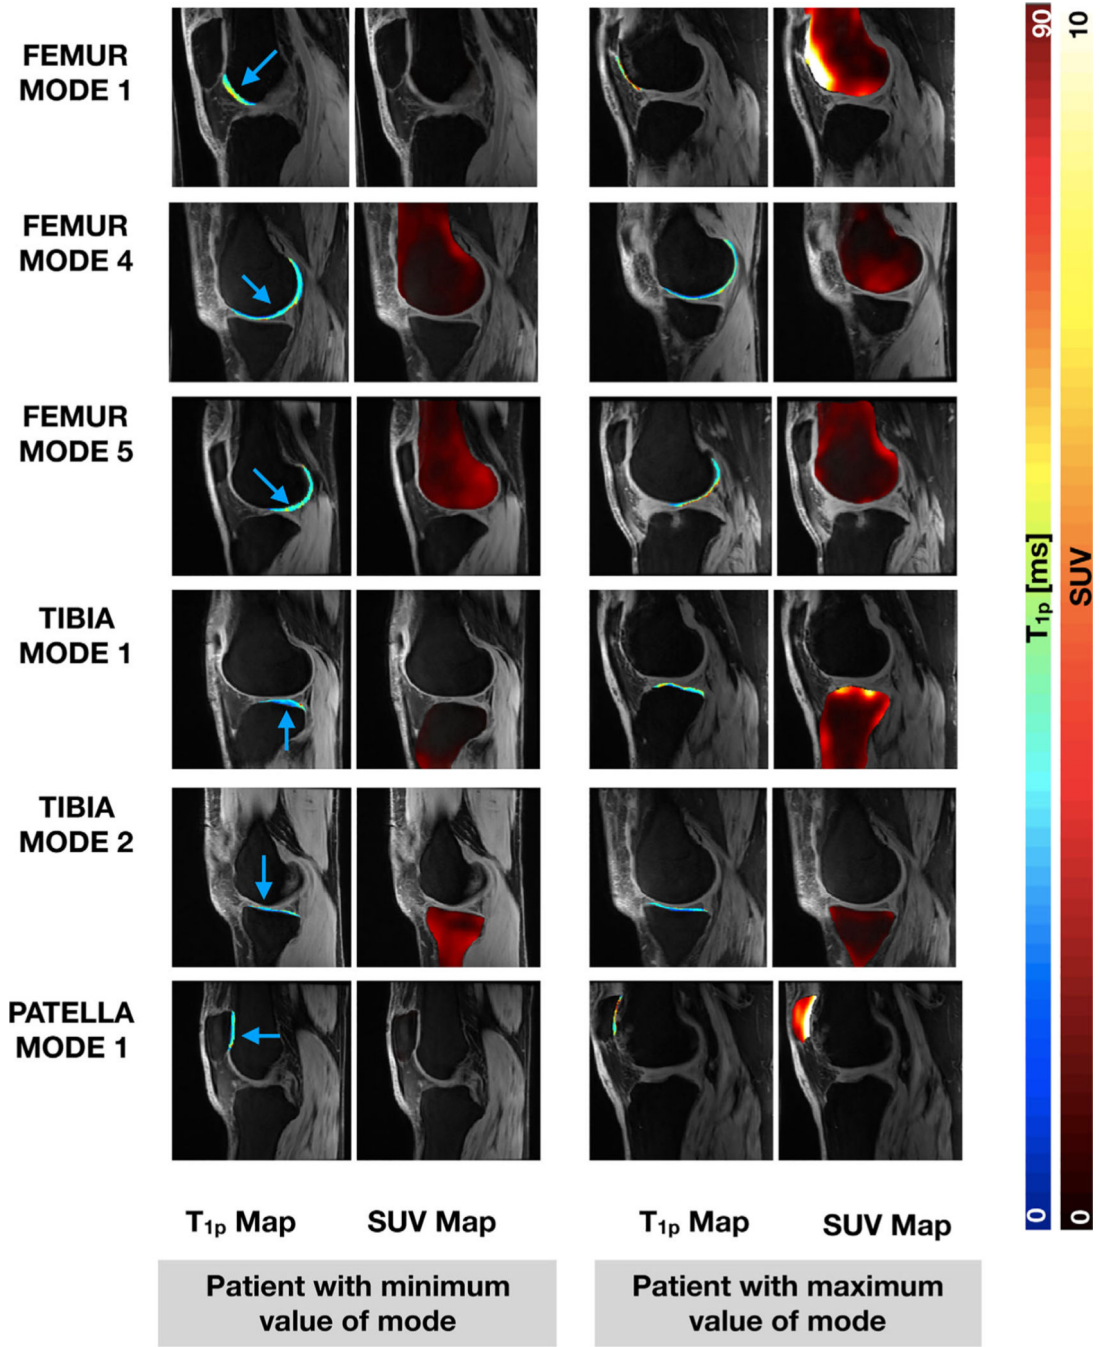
T_{1p} relaxation times and SUV maps overlaid on the first echo of the 3D T_{1p}/T₂ MAPSS sequence of patients with the minimum (left) and maximum (right) values of the modes that have associations with manifestations of OA in the femur, tibia, and patella. The blue arrow points to areas of the cartilage where the T_{1p} and/or SUVs are different between the minimum and maximum value patient.
